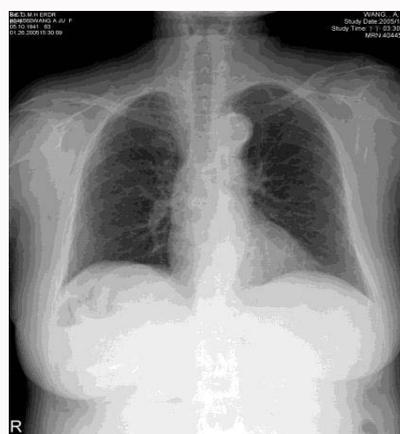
Chest roentgenogram abnormalities of consolidation has been cleared up to complete normal in 35 days follow up film.
